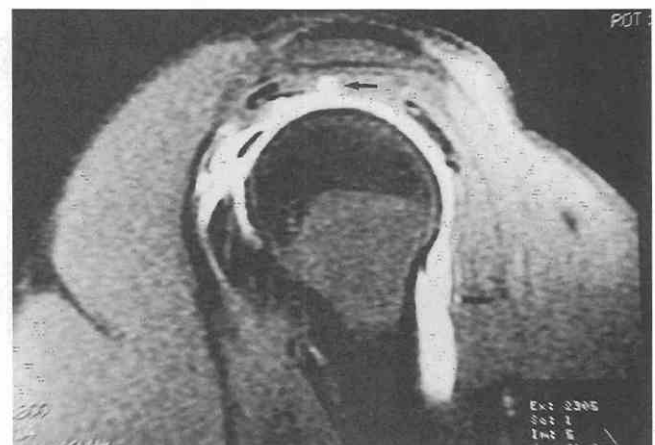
Partial tear of the supraspinatus muscle. T1-weighted (TR = 500 msec, TE = 14 msec), sagittal oblique image with fat saturation obtained after intra-articular injection of dilute gadolinium. Gadolinium fills a partial tear of the under-surface of the belly of the supraspinatus muscle (arrow). No bright signal is present in the subacromial-subdeltoid bursa, thus effectively excluding a full-thickness cuff tear.
